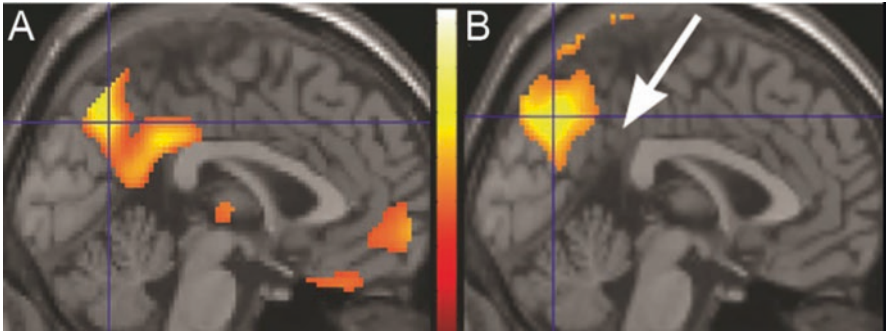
“Island sign” in Lewy body dementia (LBD). On MRI templates of the medial aspect of the brain, areas of decreased metabolism (^{18}F -FDG PET) in AD (A) and decreased perfusion (H_2^{15}O -PET) in LBD (B). Metabolism and perfusion are coupled in AD and LBD. Note involvement of the posterior cingulate gyrus in AD but sparing of this region (arrow) in LBD. (Modified from [153])
